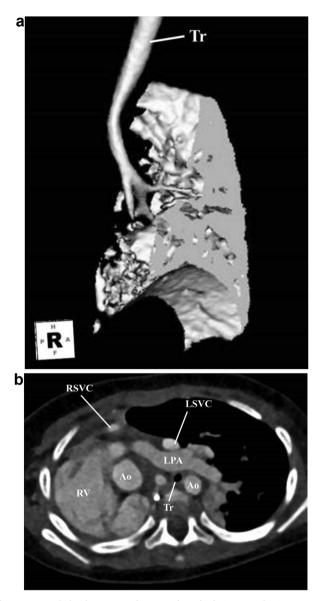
A. 3D multidetedtor computed tomography at birth. (Tr = trachea.). B. Contrast enhanced computed tomography just before slide tracheoplasty. (Tr = trachea, Ao = aorta, RSVC = right superior vena cava, LSVC = left superior vena cava, LPA = left pulmonary artery, RV = right ventricle.)
